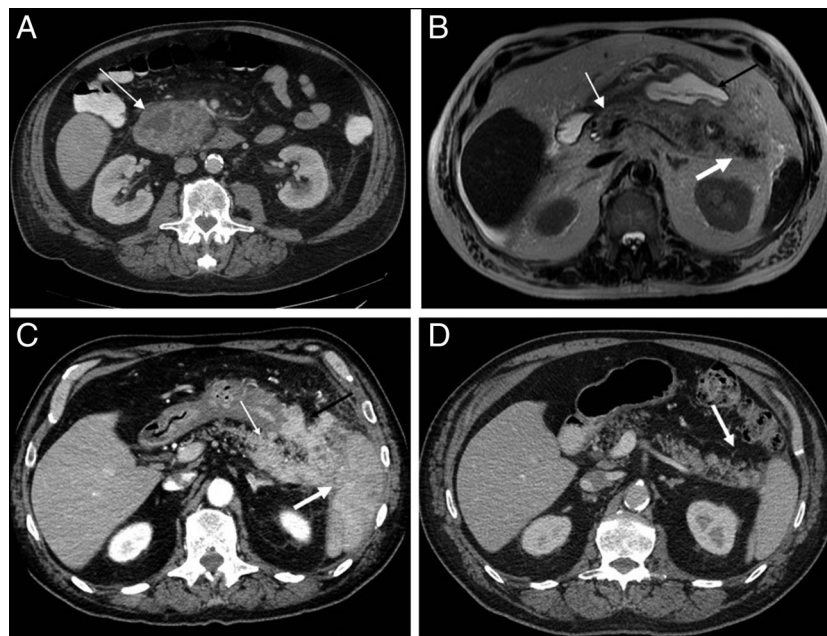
(A) Axial post contrast CT image demonstrates necrotizing inflammation of the pancreatic head (white arrow). (B) Axial T2-weighted magnetic resonance image shows improvement in the pancreatic head inflammation (white thin arrow) with new pseudocyst in the lesser sac (black arrow). There is persistent inflammation at the pancreatic tail (white thick arrow). (C) Axial post contrast CT image demonstrates infiltrative a hyperenhancing soft tissue mass at the pancreatic tail (white thin arrow), greater curvature of the stomach (black arrow), and splenic hilum (white thick arrow). The pseudocyst had resolved. (D) Axial post contrast CT image demonstrates complete resolution of the hyperenhancing soft tissue mass (white arrow). CT, computed tomography.
